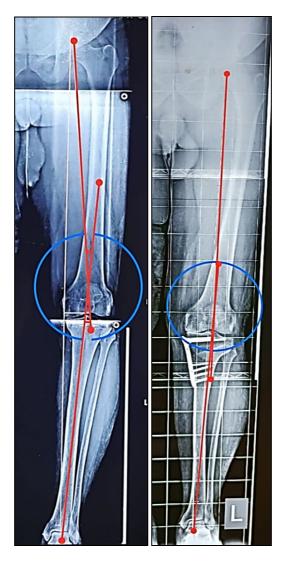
Above Radiographs showing Hip Knee Ankle Angle, preoperatively angle was 9.2° which changes to 2.2° postoperatively
